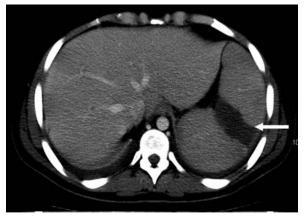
Abdominal computed tomographic scan of the case 2 patient demonstrates a splenic infarct.
